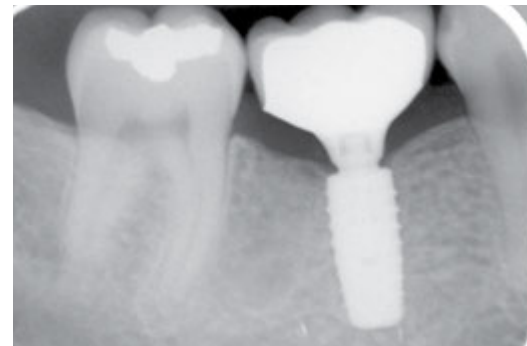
The x-ray control image shows the epicrestal placement of the implant shoulder and the anatomically created crown emergence profile.
